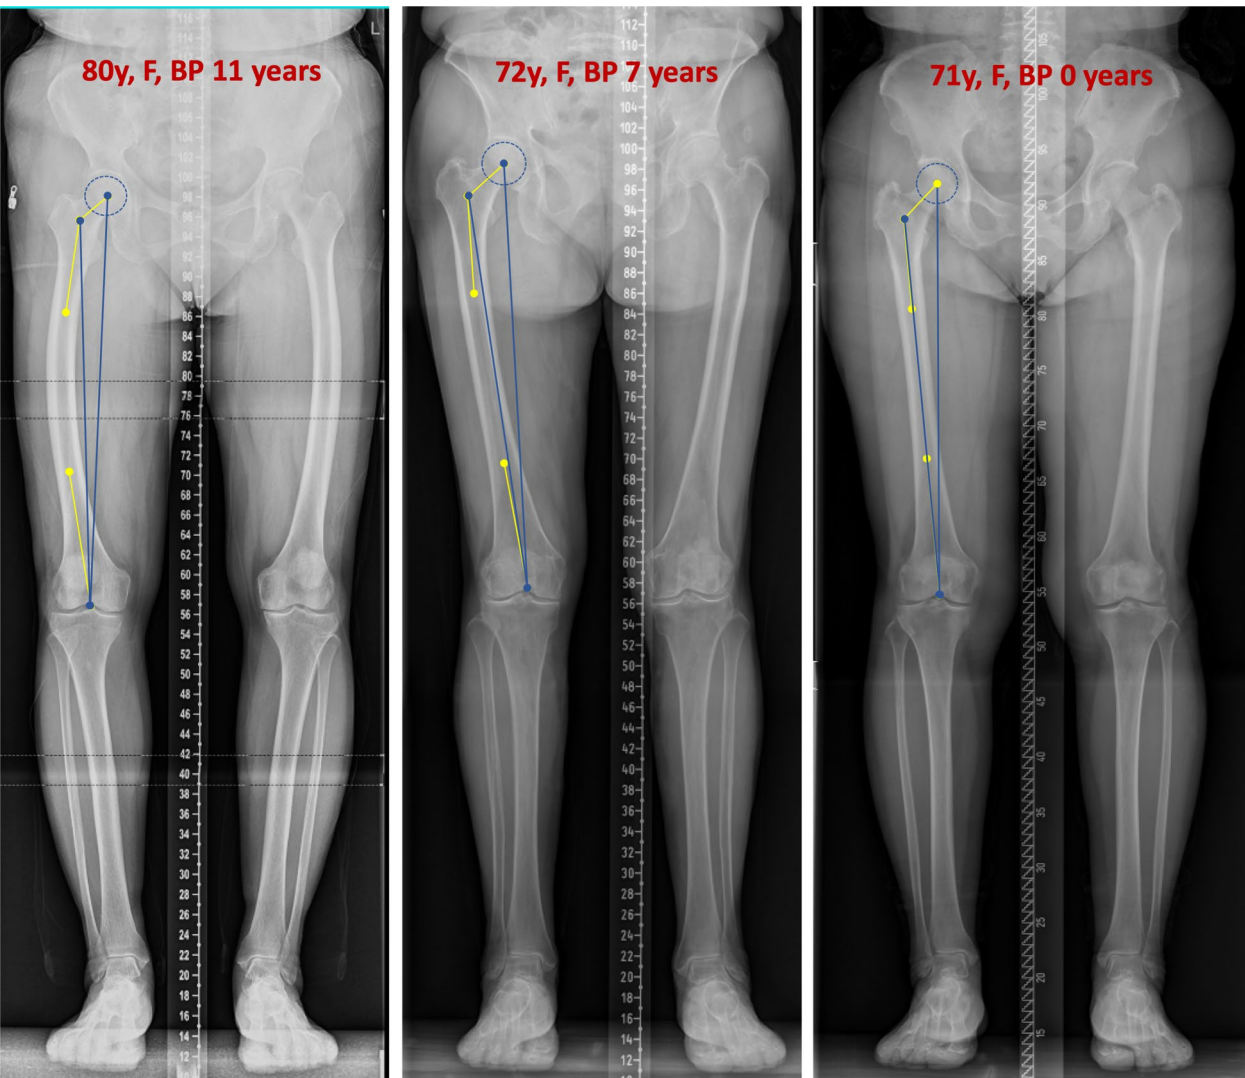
Representative lower limbs X-ray of BP users and control patients. Left: an 80-year-old woman who took alendronate sodium tablets for 11 years to prevent fragility fracture. Middle: a 72-year-old woman who took alendronate sodium tablets for 7 years to prevent fragility fracture; right: a 71-year-old woman receive lower limbs X-ray in outpatient due to joint pain
